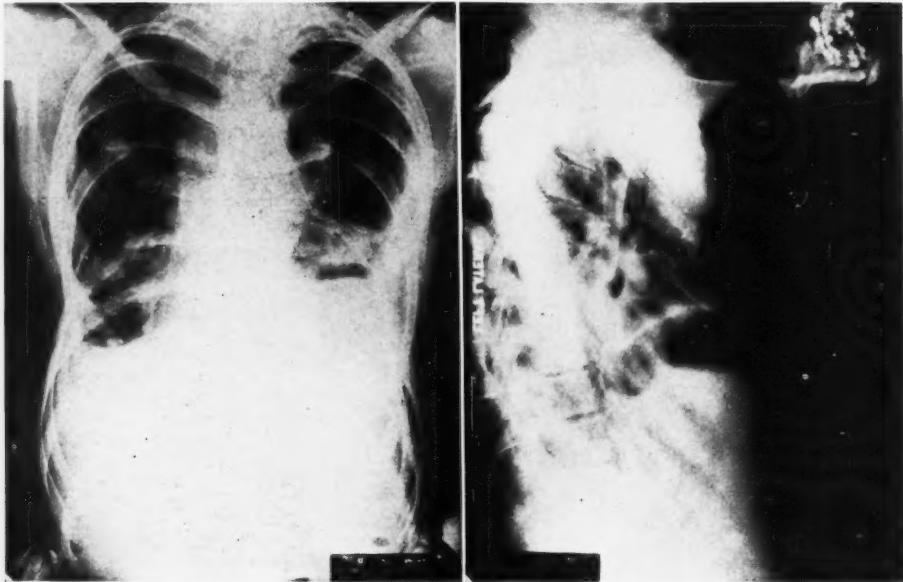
Roentgenograms of the chest taken postoperatively in November 1948.
